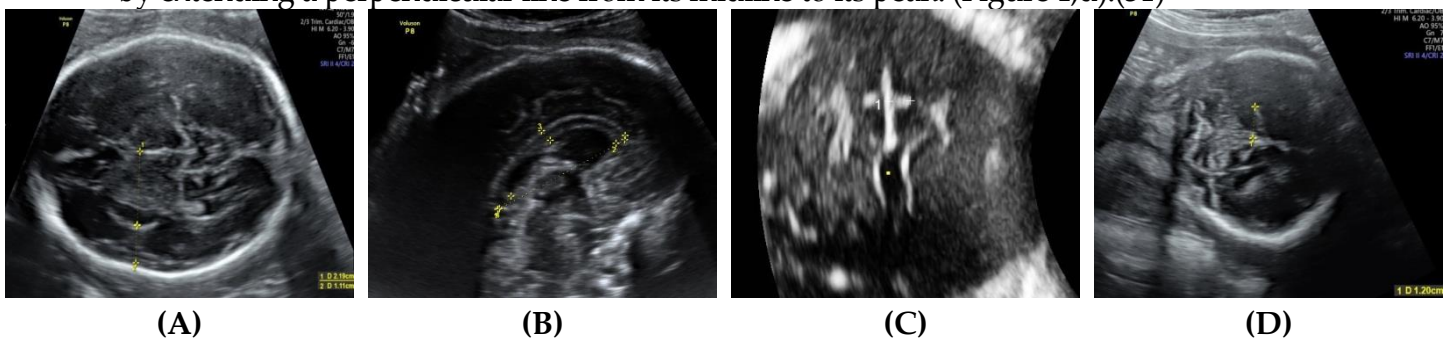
(a–d) Fetal neurosonographic images obtained in normal fetus, showing the study measurements. (a) Axial transventricular plane and measurements of insula depth and Sylvian fissure depth. (b) Measurement of corpus callosum length and thickness using 2 D ultrasound mid-sagittal plane. (c) Coronal transthalamic plane showing measurement of the cingulate fissure depth. (d) Coronal transcerebellar plane, showing measurement of the calcarine fissure depth.
